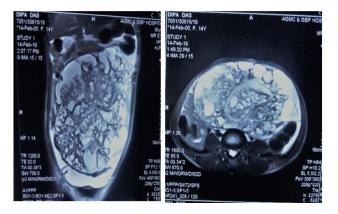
MRI revealed well encapsulated mass with heterogenous, solid as well as cystic mass in pelvic cavity with extension upward to peritoneal cavity left ovary was unremarkable.
